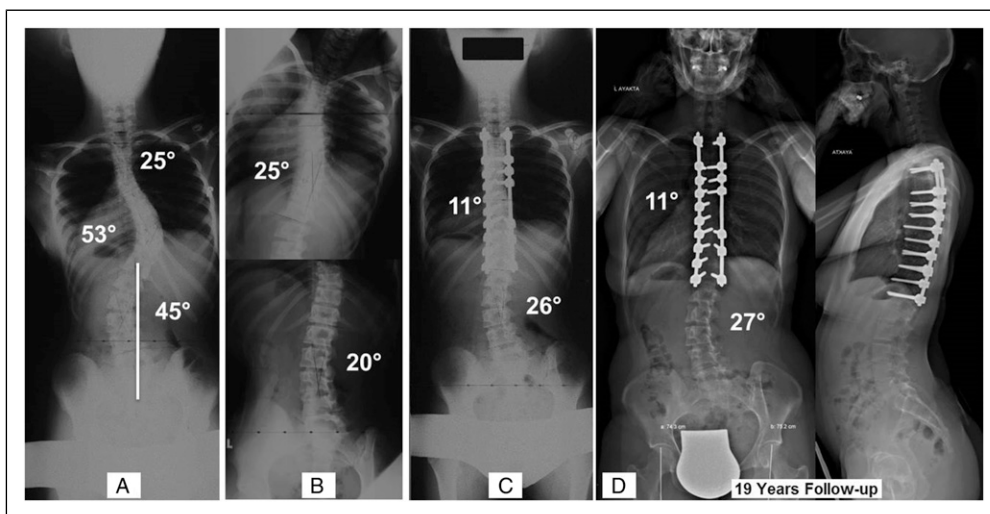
14 years female patient. A: Preop AP Standing X-ray; B: Bending X-rays; C: Early-postop AP Standing X-ray; D: 19 years Follow-up AP and LAT Standing X-rays; AP: Anteroposterior; LAT: Lateral.
